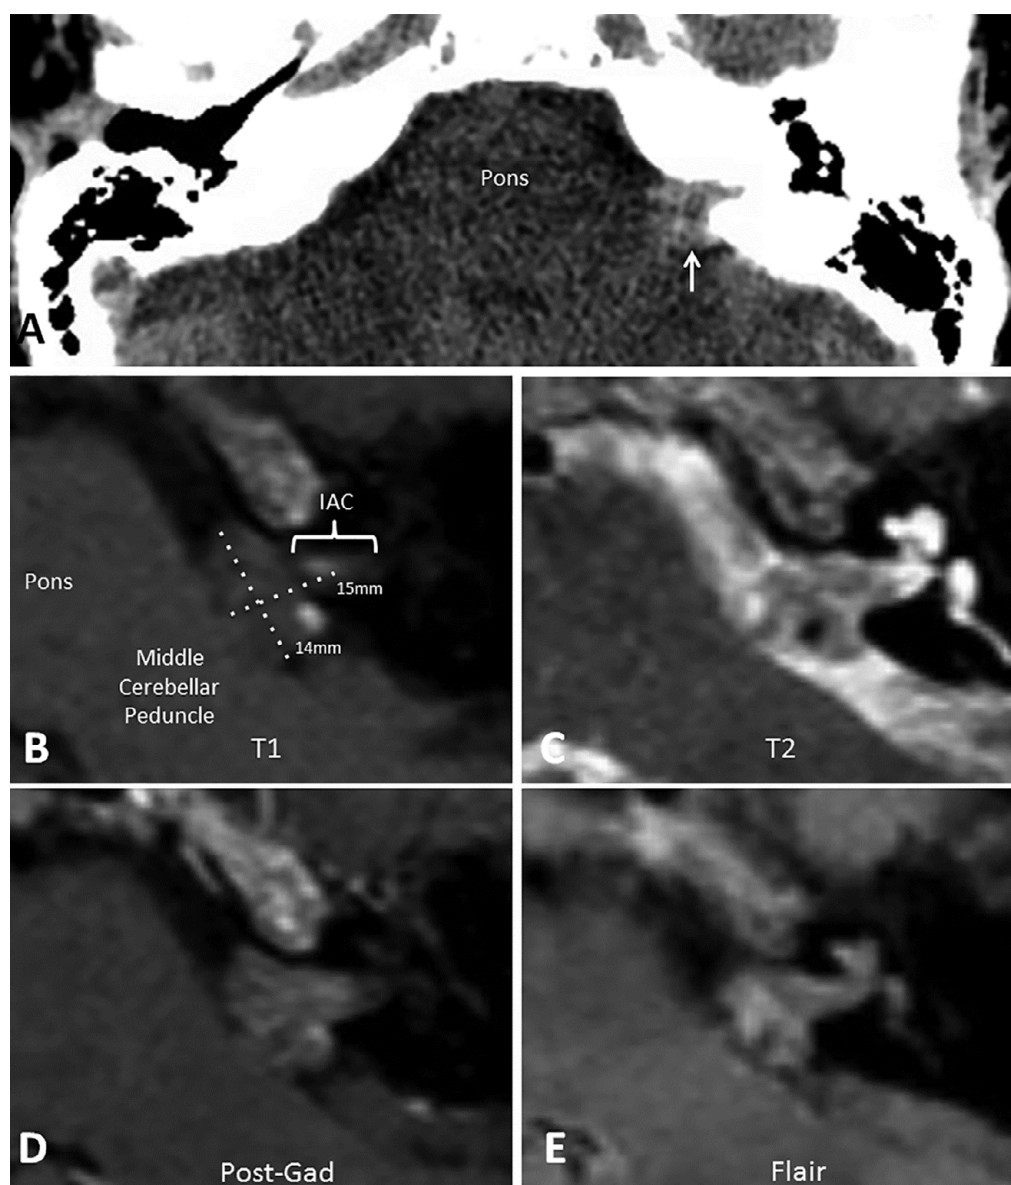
A) Axial non-contrast CT section through the mass showing some subtle high attenuation (arrow) with possibly a central calcification. Axial (B) T1-weighted and (C) T2-weighted MRI sequences showing a 15 x 14 mm extra-axial lesion in left CPA extending into the internal acoustic canal (IAC). On T1 (Fig 1B) there is an eccentric hyperintensity consistent with blood or calcification. On T2 (Fig 1C) there is a central hypointensity probably calcification. The lesion enhances slightly after gadolinium administration (D; Post-Gad) and is hyperintense on (E) FLAIR sequence compared with brainstem parenchyma.
